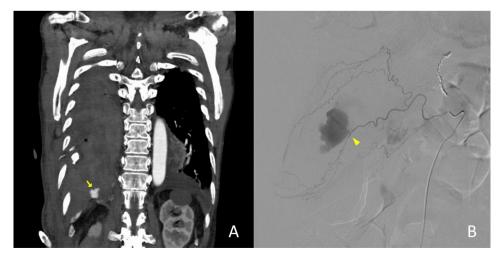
Computed tomography and angiography in Case 1. (A) Enhanced computed tomography revealed a right hemothorax with contrast extravasation near the fractured rib. (B) Angiography demonstrated active bleeding from the right inferior phrenic artery
